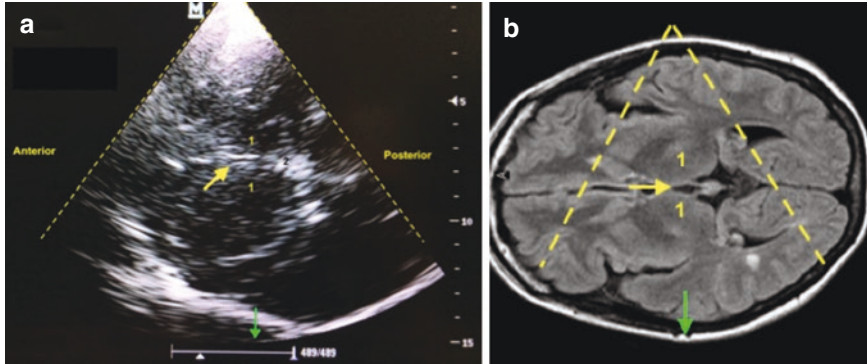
(a) Diencephalic plane by TCCS through of transtemporal acoustic window: (1) thalamus, (2) pineal gland, (yellow arrow) third ventricle and (green arrow) contralateral skull; (b) brain MRI: (1) thalamus, (yellow arrow) third ventricle, (dotted line) ultrasound beam through transtemporal window and (green arrow) contralateral skull. (Author: Camilo N. Rodríguez)
